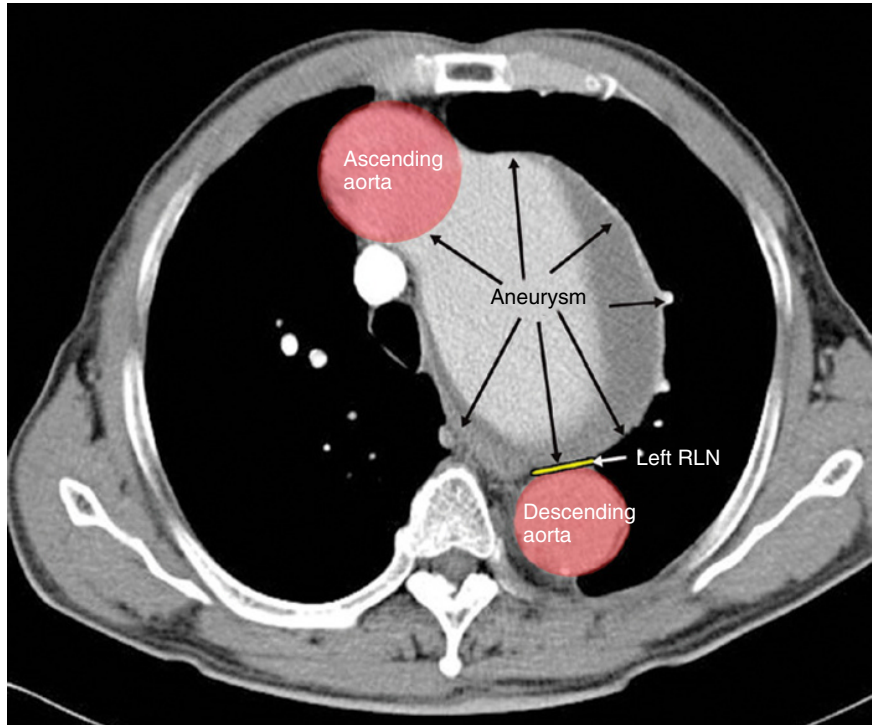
Axial (transverse) CT image of the patient described in the case of Ortner's syndrome. Note how the left RLN is compressed by the aneurysm. Courtesy of Dr. Rong-Feng Chen.
